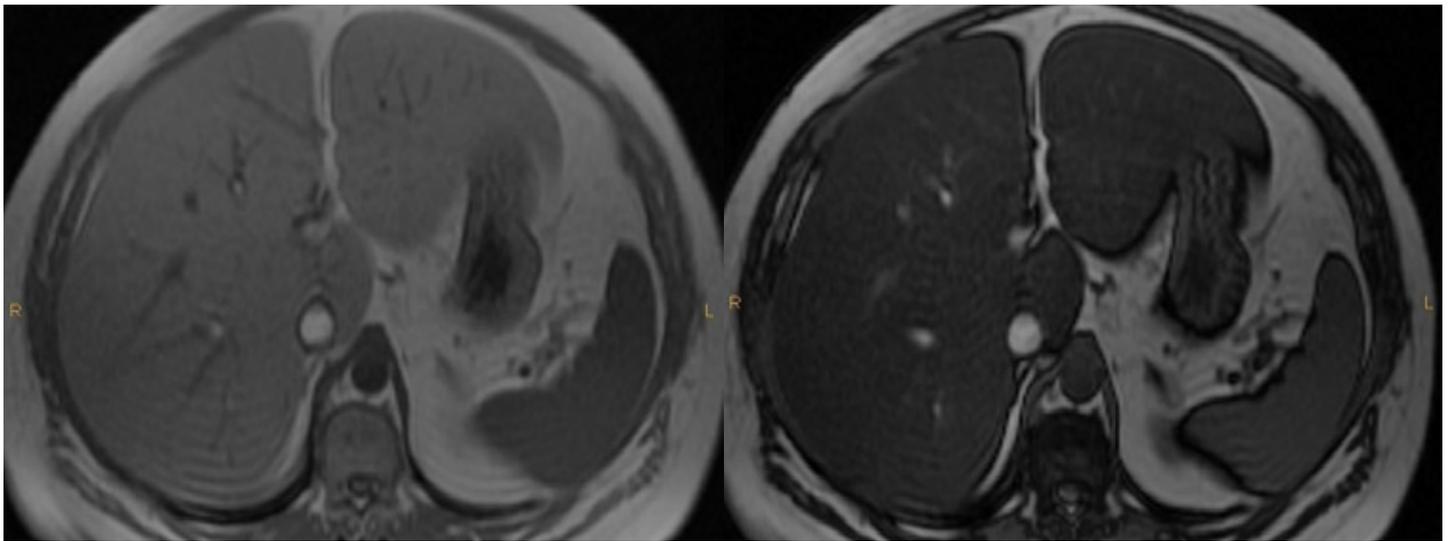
T1 in-phase MRI (left) and T1 out-of-phase MRI (right) shows liver signal loss on out-of-phase image (same patient as figure 3).
